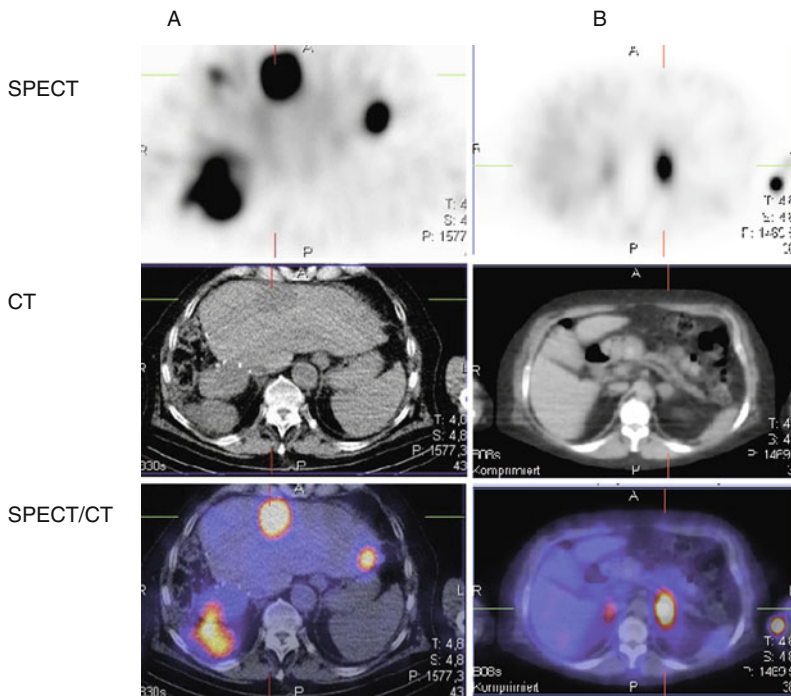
[^{123}I]-Iodometomidate SPECT of a 68-year-old patient with cortisol-producing ACC and liver metastases (a) and a 55-year-old patient with nonfunctioning adrenal adenoma at the left side (b)
